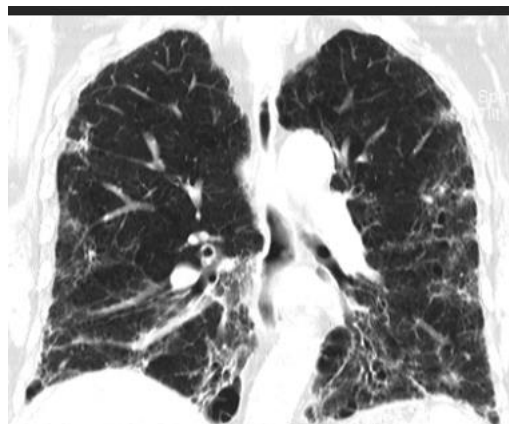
A 70-year-old man's chest CT thorax images reveal diffuse ground glass opacities in both lungs, with some apico-basal gradient and tiny cysts or hyperlucent spaces. The CT thorax image shows extensive reticulations, architectural distortion, ectasis of bronchi and bronchioles, and hyperlucency of intervening areas.
